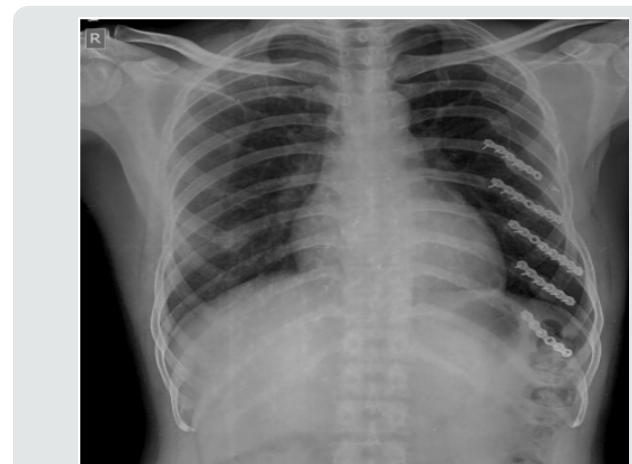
Anteroposterior chest radiograph at 7 months following surgery showing fracture consolidation.
